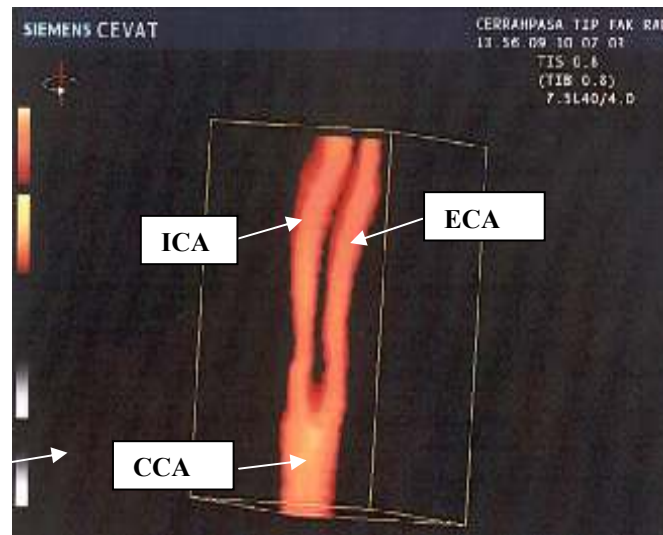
The geometry of the stenosed carotid artery taken by Color Doppler Ultrasound Imaging technique.
